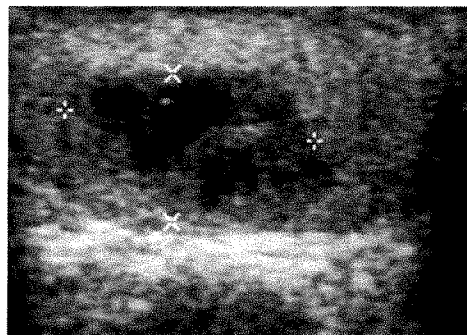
Infarct. Sonogram shows well-defined hypoechoic mass (cursors) with irregular cystic spaces mimicking tumor.
